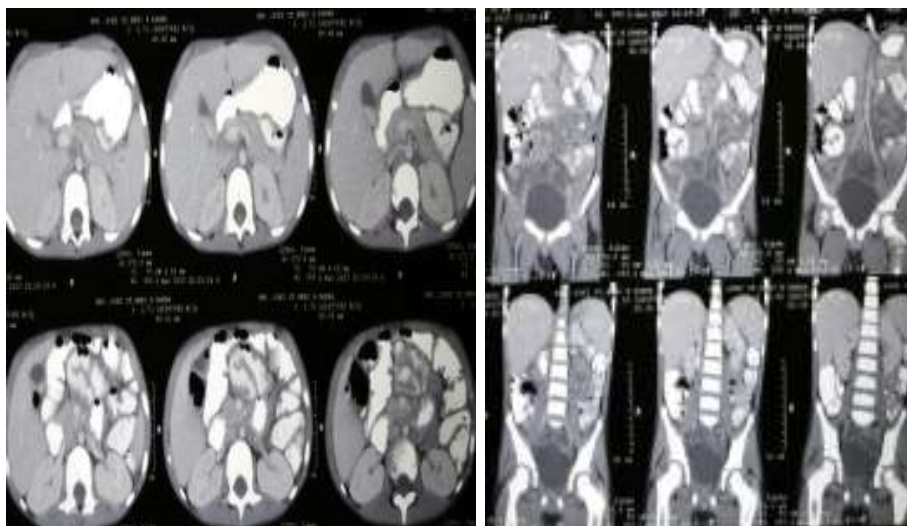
(a) CECT image oriented parallel to the longitudinal plane of the intussusceptions. Figure 2b. CT image oriented parallel to the longitudinal plane of the intussusception demonstrates a Jejunal
